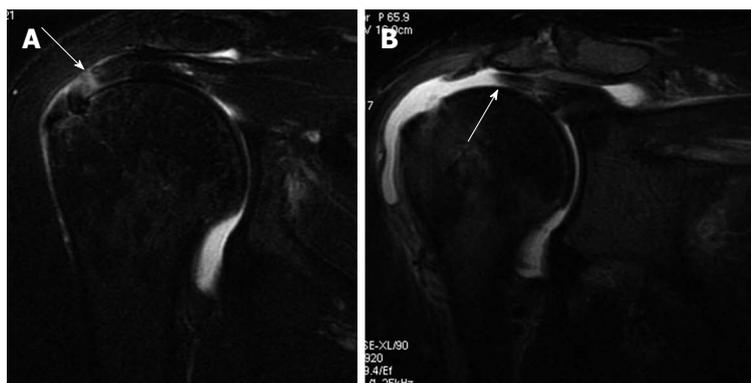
Full-thickness supraspinatus tendon tears in two different patients. A: Coronal oblique fat-sat T2-weighted image shows full-thickness supraspinatus tendon tear without significant tendinous retraction (arrow); B: Coronal oblique fat-sat T2-weighted image in another patient shows torn retracted supraspinatus tendon (arrow).
